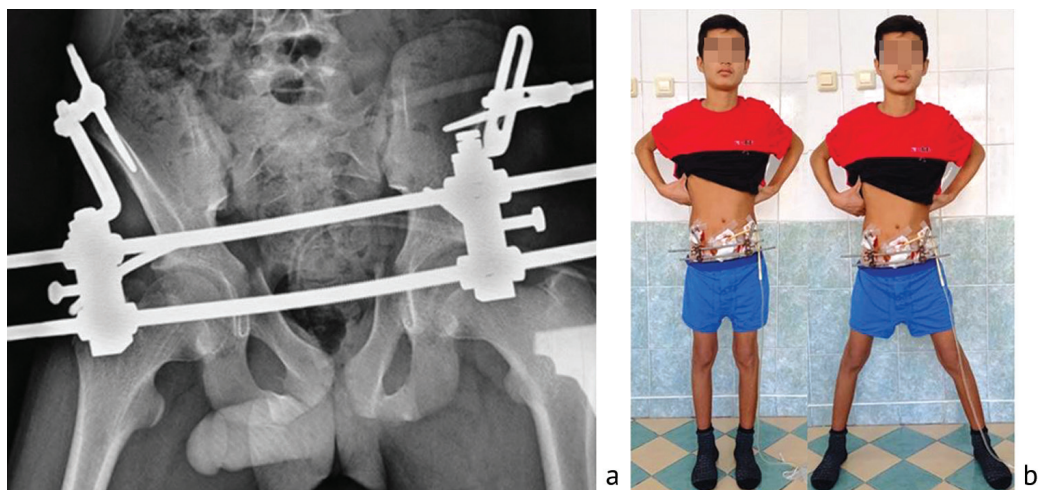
The period of rehabilitation treatment: *a* X-ray of the pelvis with EFD fixation; *b* photo during treatment, exercise therapy
